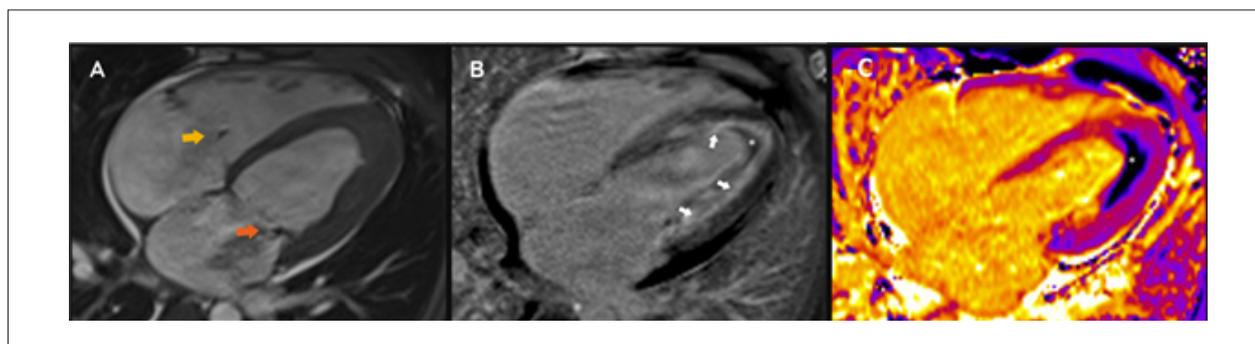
(A) Cine magnetic resonance imaging showing attachment of the papillary muscles to the lateral wall of the LV with loss of trabeculation and mitral (orange arrow) and tricuspid (yellow arrow) regurgitation jets. (B) Delayed enhancement showing diffuse circumferential subendocardial fibrosis, without corresponding to a coronary territory (white arrows) and associated with thrombus covering the left ventricular subendocardium (asterisks). (C) Native T1 mapping showing diffusely increased T1, mainly in the septal wall, indicating edema and fibrosis, associated with the thrombus (asterisk).
